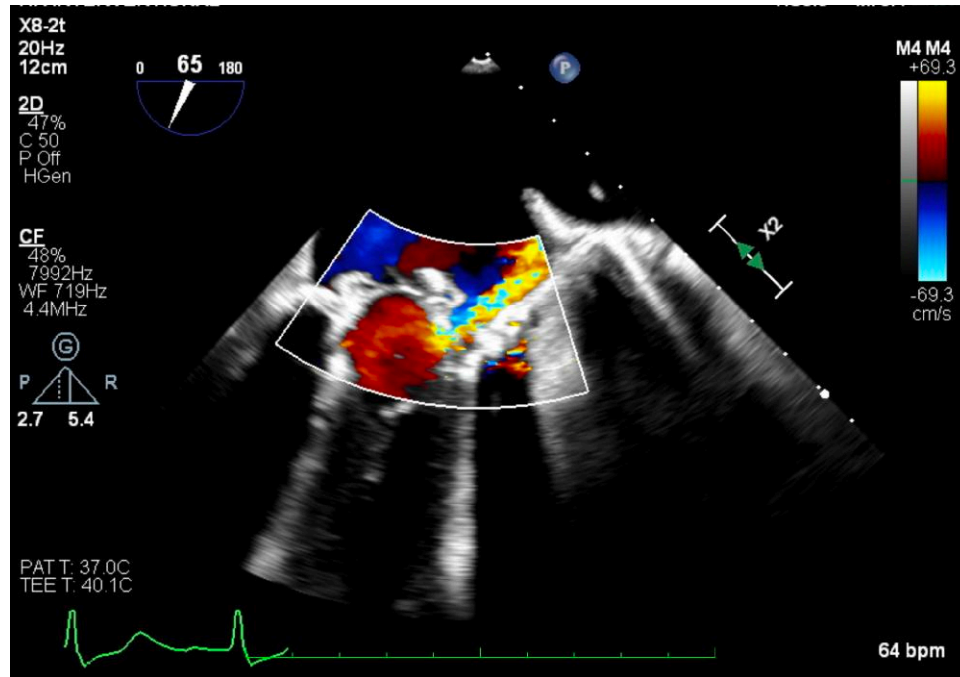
Residual paravalvular leak in 2D echocardiogram.
